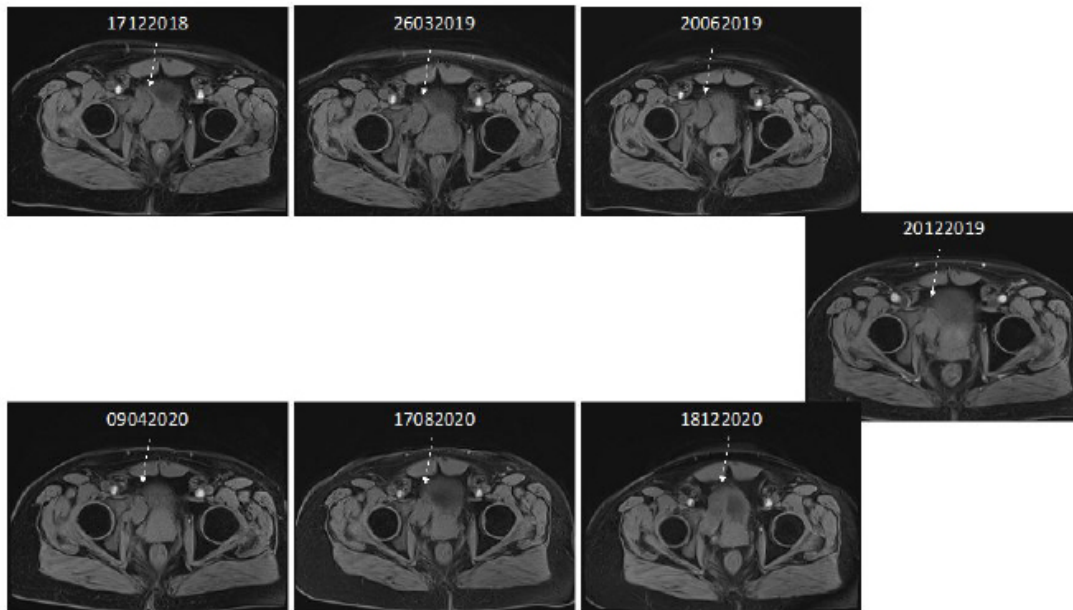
MRI images over the course of the metastatic and palliative stages.
